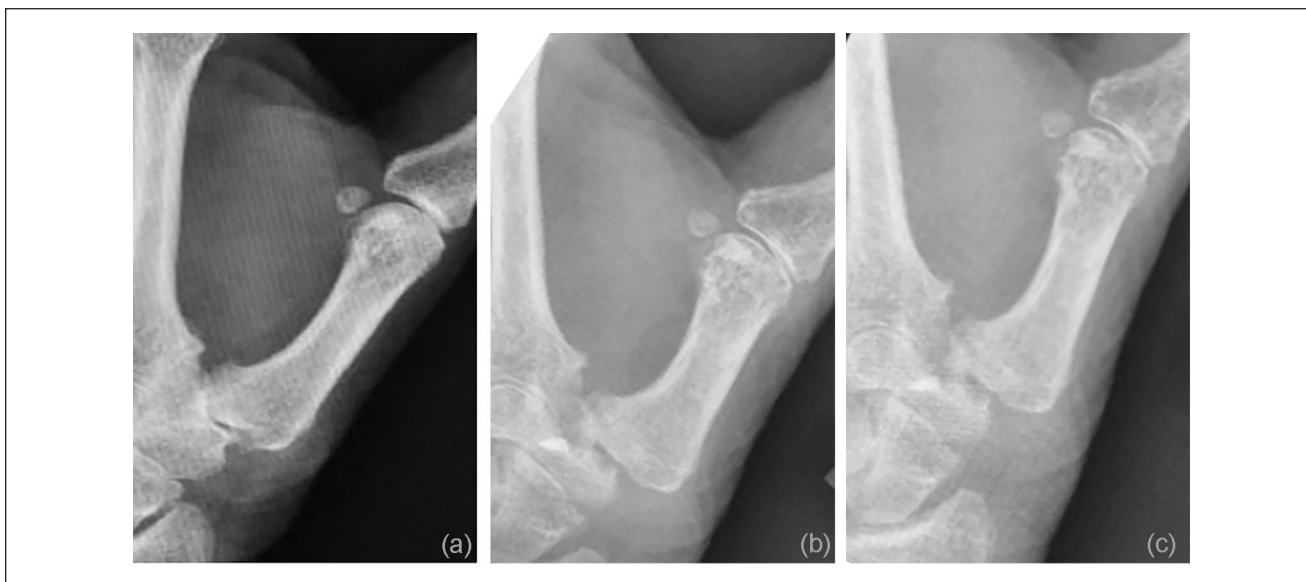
(a) Preoperative radiograph demonstrating joint space destruction. (b) Postoperative radiograph at 6 weeks after arthroplasty with meniscal allograft. (c) Postoperative radiograph at 1 year demonstrating maintenance of the arthroplasty space.
